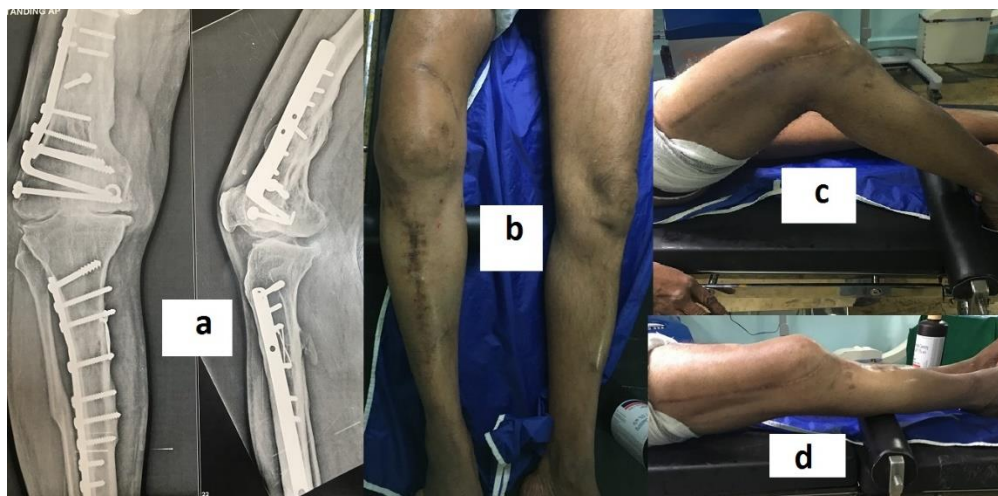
a): Preoperative x-ray showing osteoarthritic knee with old implants around the knee; b): Varus of 23 degree; c): Knee rom upto 70 degree d) 15 degree FFD
